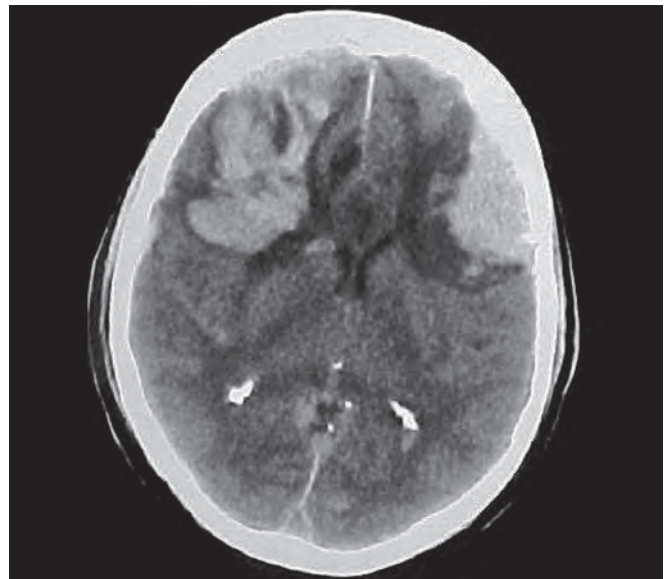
CT scan of a patient with bilateral frontal contusions
